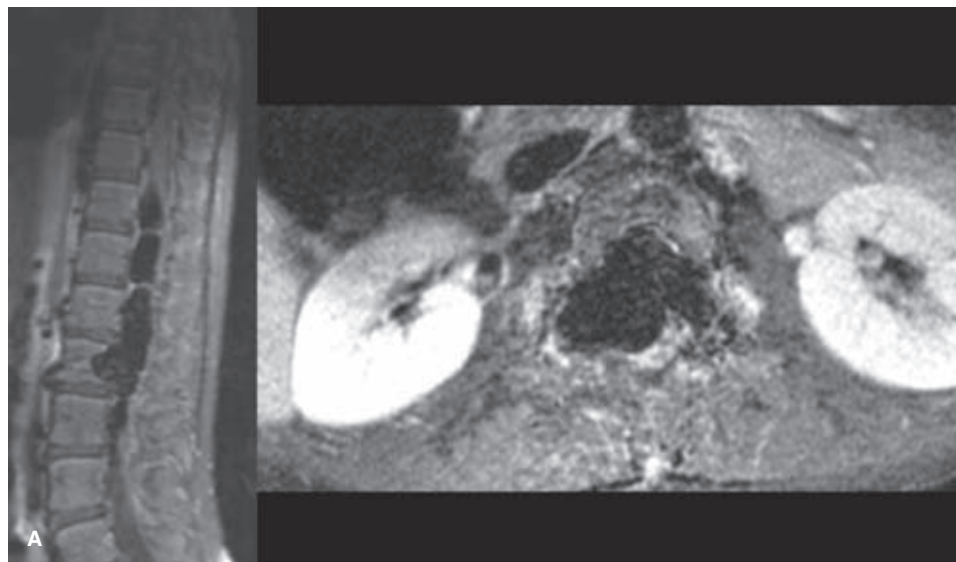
(A–E) Paraspinal AVM in a young child. This girl presented with high-output cardiac failure, a bruit over the lower back, and scoliotic deformity. Her cardiologist astutely noted that the contrast from her ventriculogram returned to the heart more quickly than normal, leading to the eventual discovery of this large lumbar paraspinal malformation. The treatment for this lesion predated the availability of Onyx and was staged over several years. The initial MRI (A) showed massive distention of the intracanalicular veins and permeative remodeling of the lumbar bodies, particularly L2. (*continued*)
